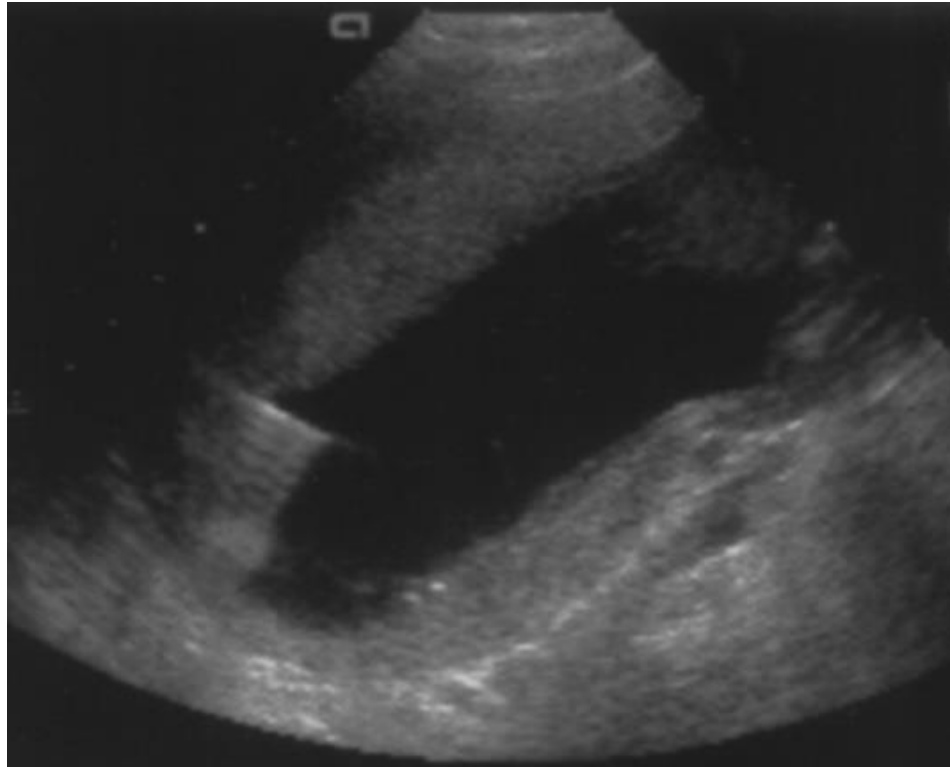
Ultrasound showing needle insertion during amniocentesis (48)
